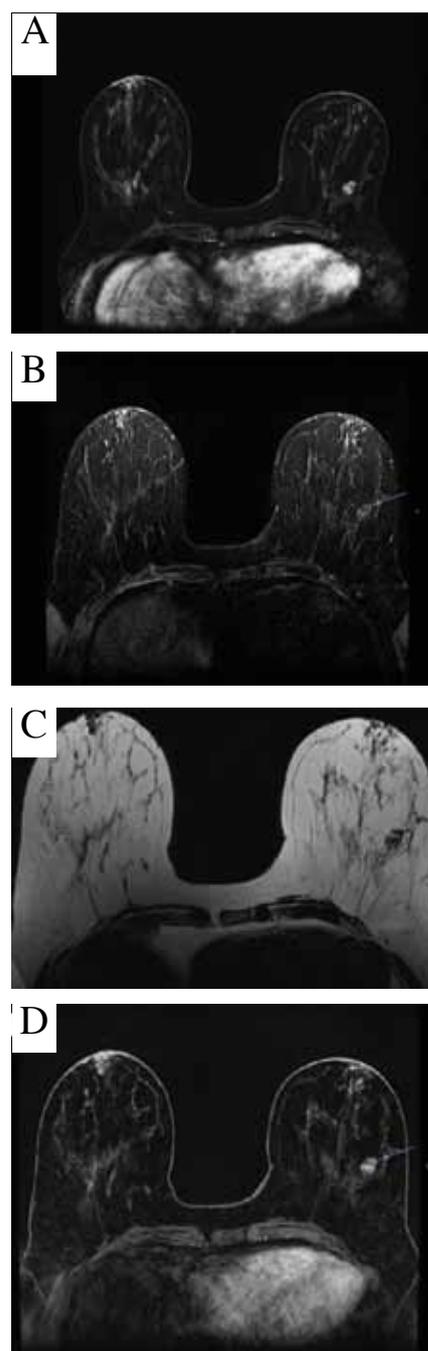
Breast magnetic resonance imaging (MRI) of a 51-year-old woman with a strong family history of breast cancer
